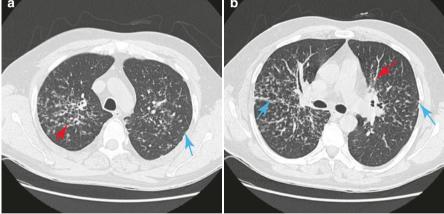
(a) HRCT of the lungs: nodulations peribronchovascularly. (b) HRCT of the lungs: nodulations peribronchovascularly and on the pleura. (c) HRCT of the lungs: nodulations peribronchovascularly and on the fissure. (d) HRCT of the lungs (coronal reconstruction): nodules on the interlobar fissure. (e, f) HRCT of the lungs (sagittal reconstruction): nodulations on interlobar fissure
